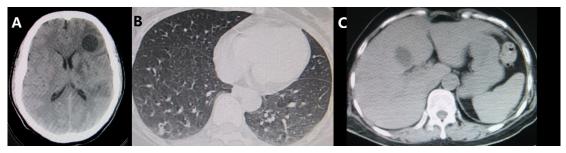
The features of brain / chest/abdominal computed tomographic (CT) images; Figure 1 A-C is from a 57 year-old female patient with fever 2 days and drowsiness 1 day was admitted. On day 1, brain CT showed the focus of infection and diffuse edema (A), chest CT showed bilateral pneumonia(B), and abdominal CT showed the focus of infection (C), On days 3, fever up to 39.0°C, On days 3 blood pressure drop to 81/54mmHg, and deep coma, On days 4, she died and was discharged.
